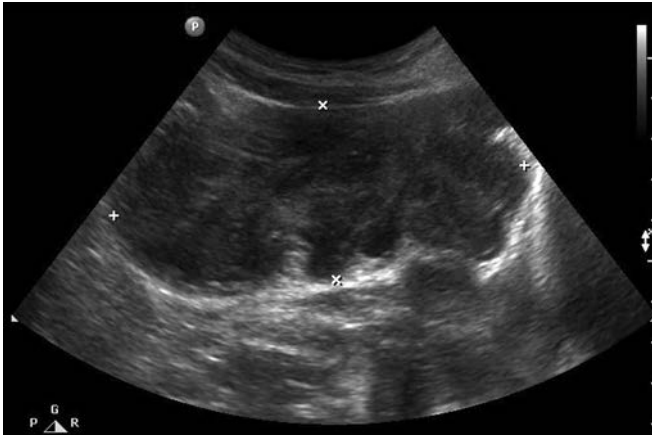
Bladder ultrasonogram showing an indwelling mass.
